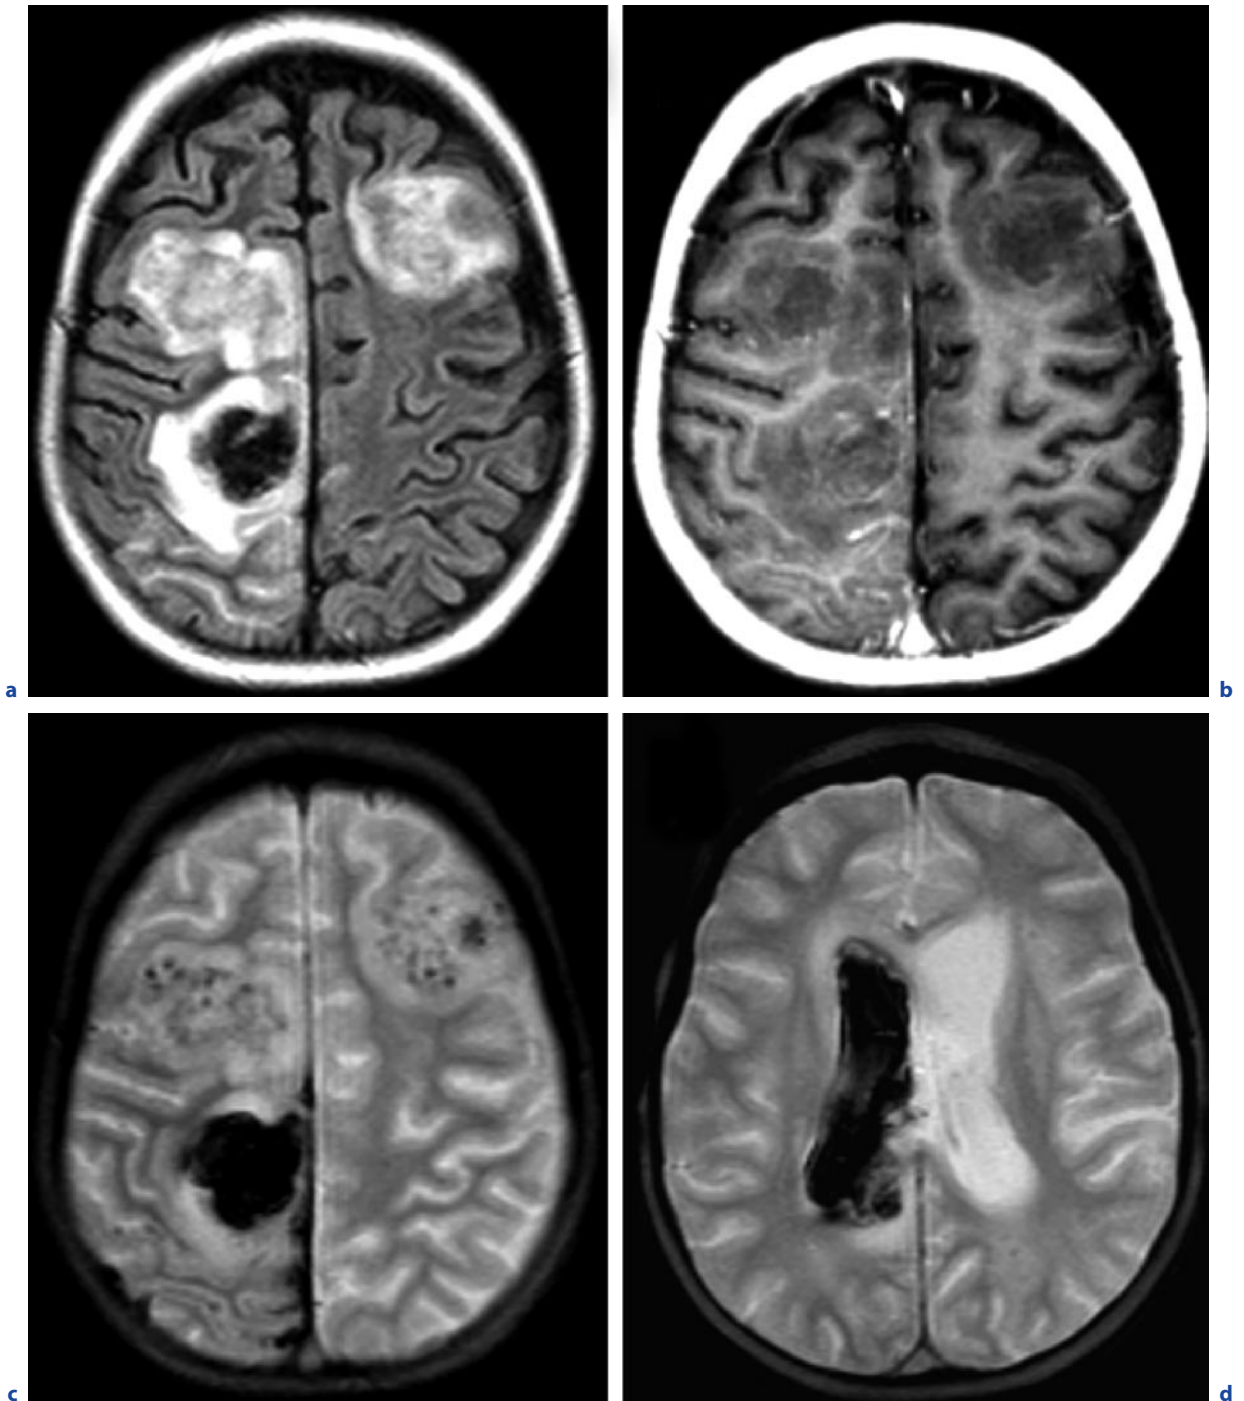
Multiple aspergillomas. a Axial FLAIR image. b Axial T1-weighted image after contrast administration. c,d Axial T2*-weighted images. Space-occupying lesions with marked surrounding edema (a). Contrast enhancement is faint (b). Due to the vasodestructive propensities of *Aspergillus*, the masses display hemorrhagic transformation, best visualized on T2*-weighted images (c,d). Also intraventricular hemorrhage is evident (d)
